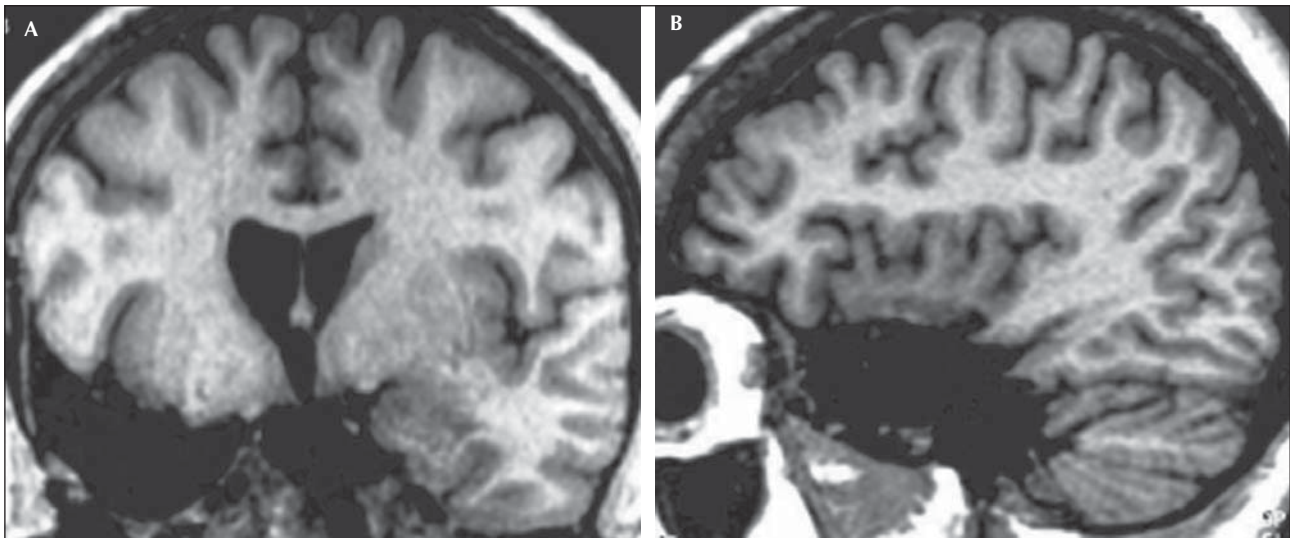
Post-operative MRI in patient 1 shows that the mesial temporal structures have been appropriately removed, whereas only a very limited portion of the inferior aspect of the ipsilateral insula has been resected.
